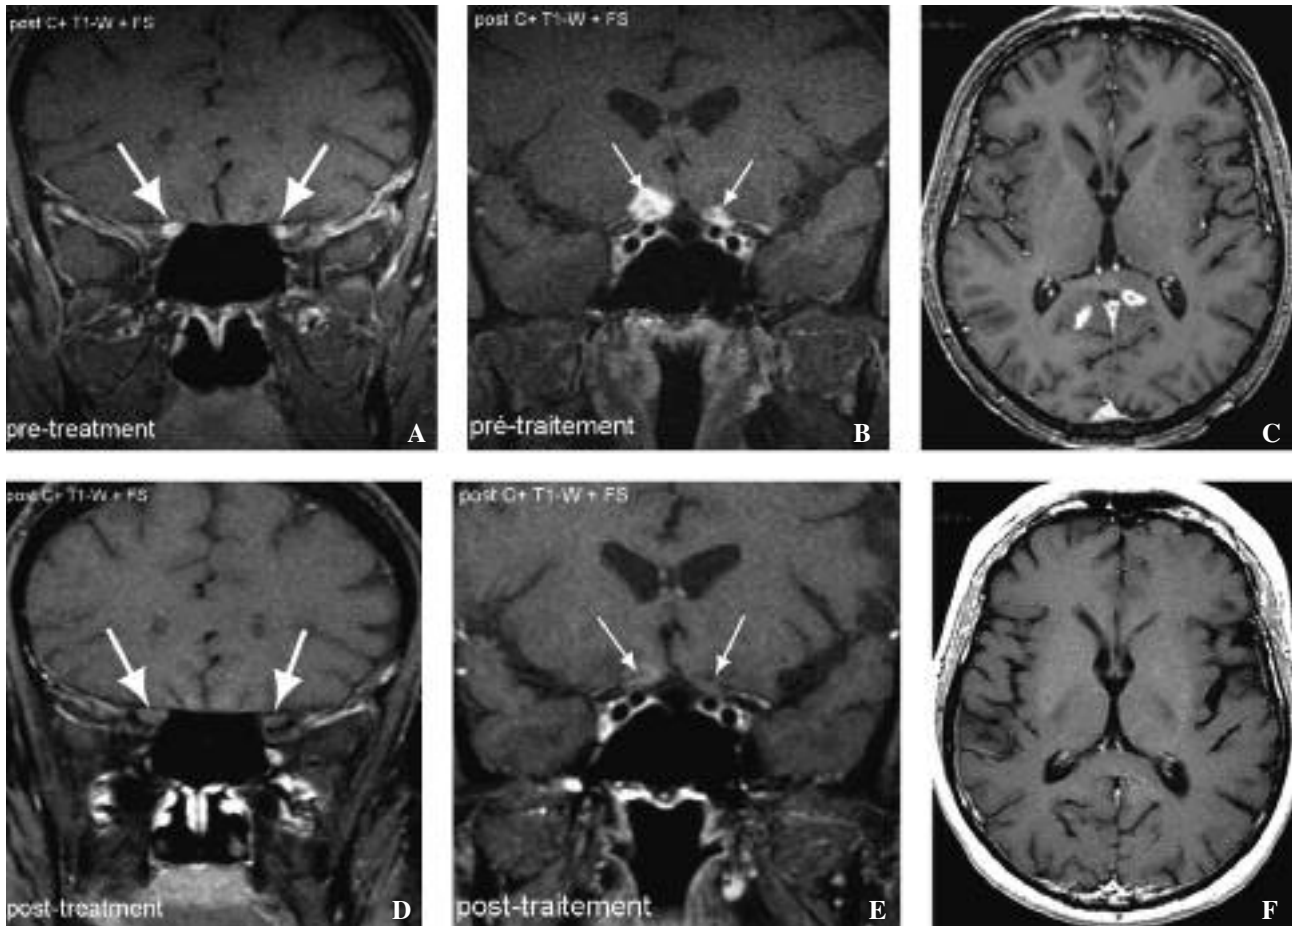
Comparative pre- and post-treatment cranial MR images of patient #2.
